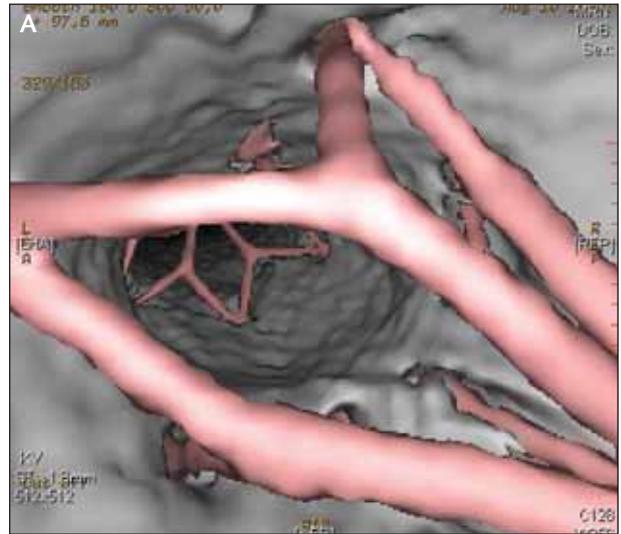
When an IVC filter with cross-links becomes deeply embedded in the wall of the IVC, removal of the filter requires moderate force and will result in shreds of endothelium at the site of removal. A CT endovascular reconstruction confirmed deep embedding of the central filter struts of an OptEase IVC filter (Cordis Corporation, Bridgewater, NJ) (A). An axial CT image showed that the endothelium covers a closed section of the filter limbs (B). The venogram after removal shows a ragged collection of endothelial tags that had previously covered the filter limbs (C).
